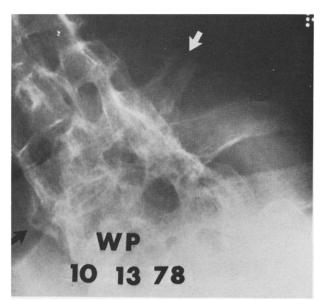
Case 3. Cervical roentgenogram demonstrating a fracture through the sixth and seventh cervical vertebrae interspace extending through the posterior elements and bisecting the sixth cervical vertebra spinous process (white arrow). Callus formation is noted anterior to the fracture region (black arrow).
